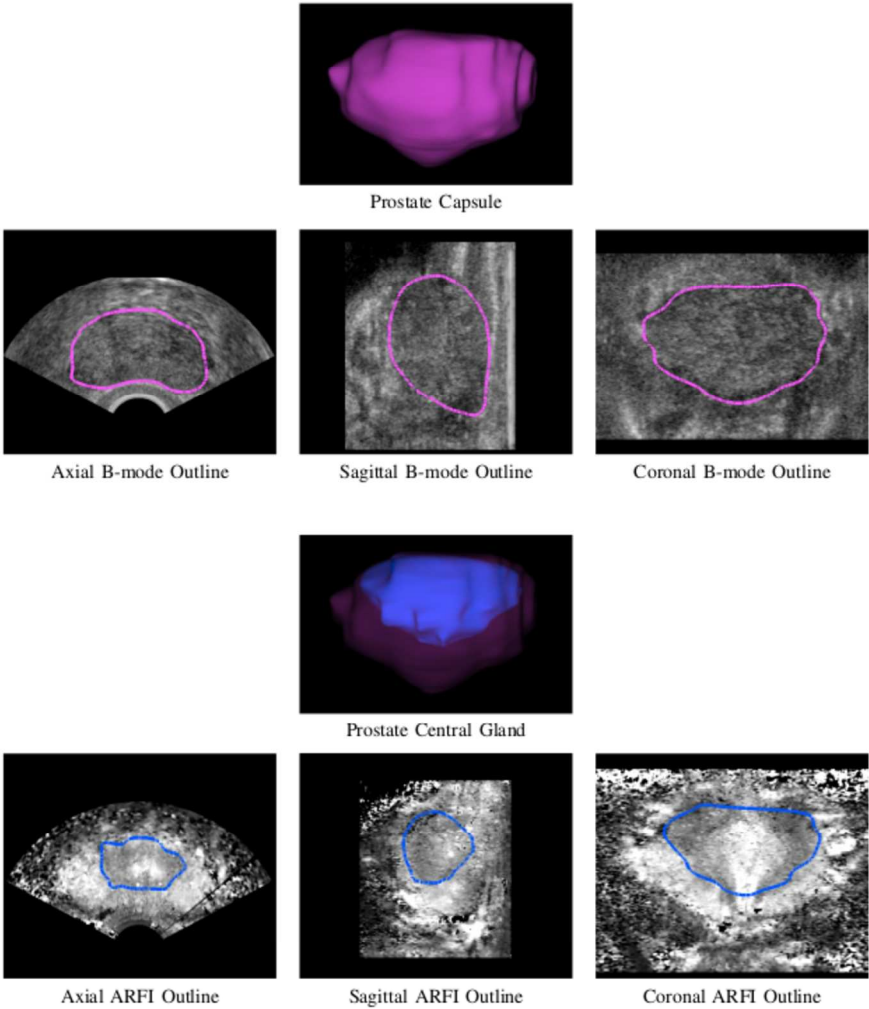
Representative ultrasound prostate models from this study. TOP ROWS: Prostate capsule 3D model (magenta) rendered from manual segmentation of the B-mode images, with the 3D model outlines superimposed on the central axial, sagittal and coronal B-mode images. The primary segmentation plane was sagittal; however the axial and coronal planes were used to guide the segmentation to ensure 3D continuity of the capsule structure. BOTTOM ROWS: Prostate central gland 3D model (blue) inside prostate capsule 3D model (magenta) rendered from manual segmentation of the ARFI images, with the prostate central gland 3D model outlines superimposed on the central axial, sagittal and coronal ARFI images. The coronal ARFI imaging plane was the primary orientation used for image segmentation, but like capsule segmentation, the orthogonal planes were used to ensure continuity of the central gland in all three dimensions.
